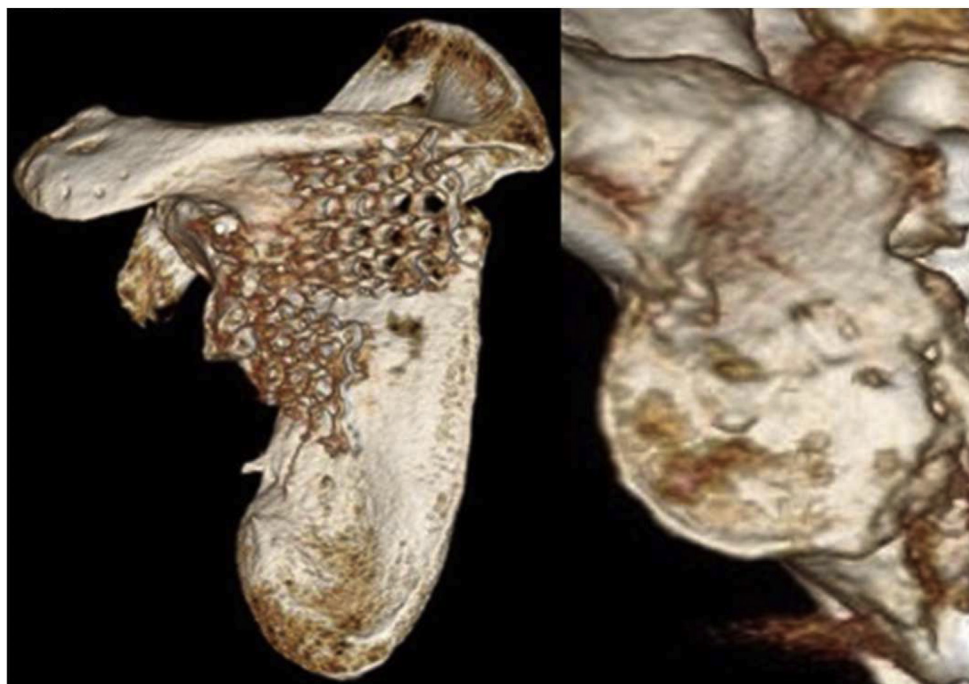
CT on the first postoperative year showing good reduction and osteosynthesis of the glenoid fossa. CT, computed tomography.
